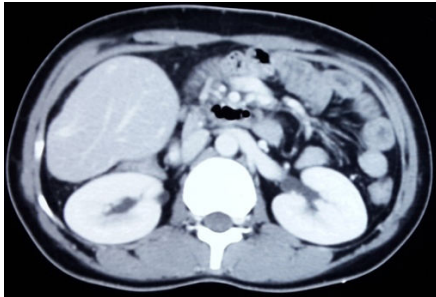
CT abdomen axial section showing accessory liver with same attenuation.
